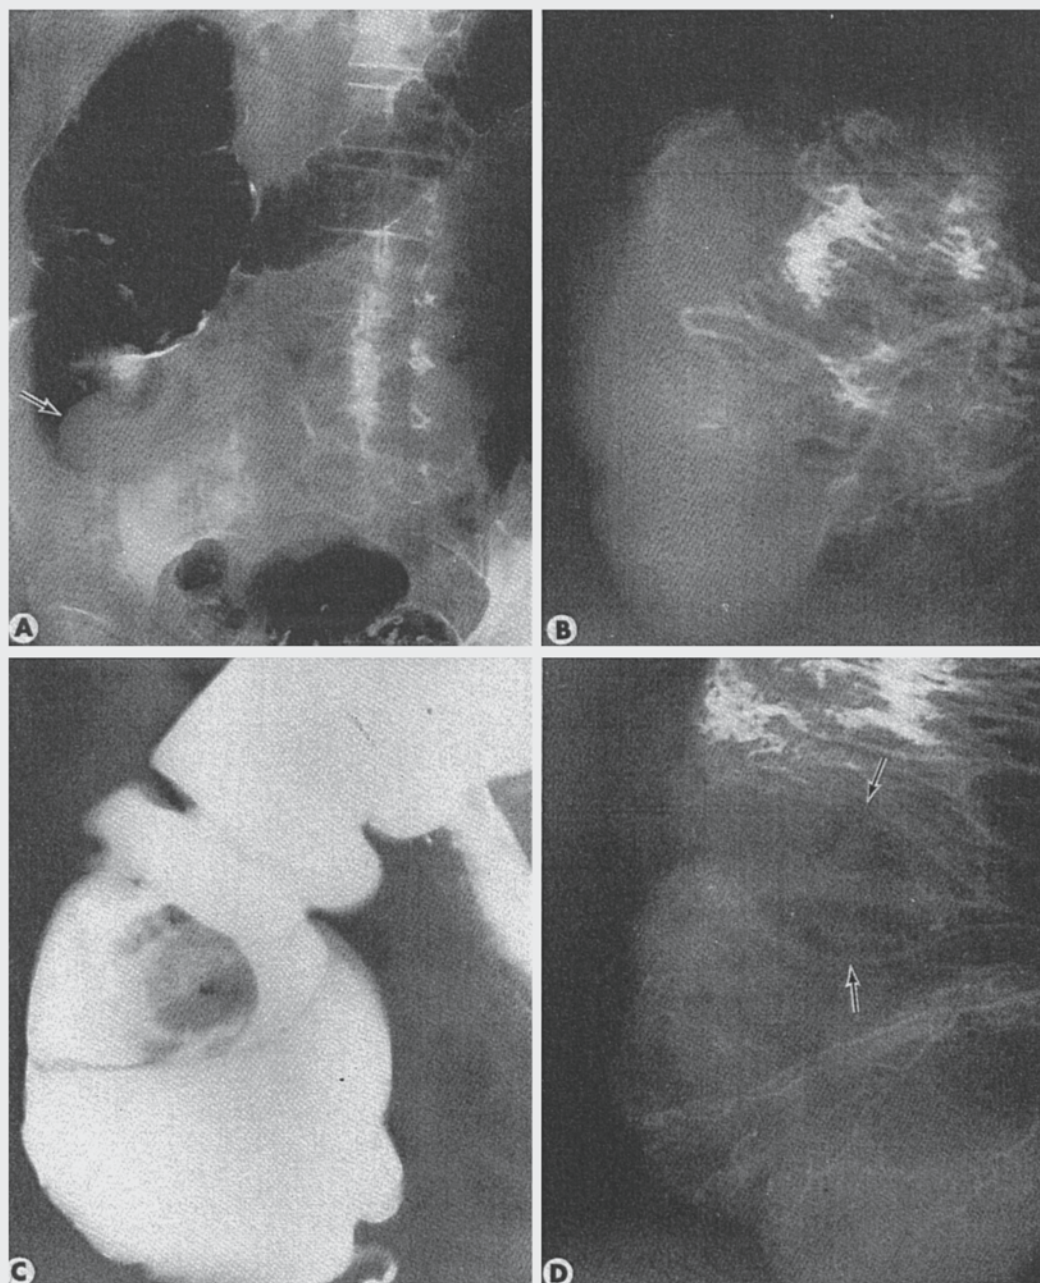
(*A* and *B*) Mucocoele of the appendix. (*A*) A large rounded filling defect is seen on the medial aspect of the cecum (arrow). (*B*) An operative mesenteric arteriogram shows the lesion to be relatively avascular. Only a few vessels are seen coursing on the surface of the tumor, in sharp contrast to the numerous vessels in the mesentery. (*C* and *D*) Lipoma of the cecum. (*C*) A spot roentgenogram of the cecum obtained during barium enema study shows a smooth rounded defect. (*D*) An operative mesenteric arteriogram shows the lesion to be radiolucent and relatively avascular. Only a few vessels are seen coursing on the surface.
